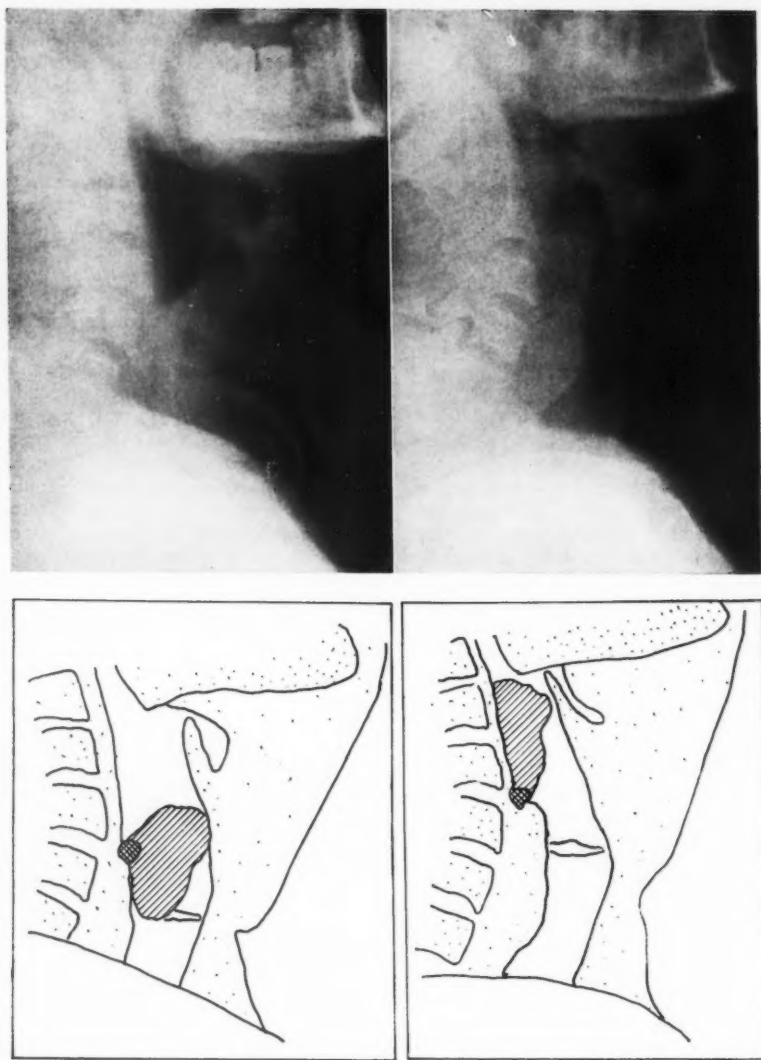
Lateral roentgenogram of the neck, showing a large pedunculated extrinsic carcinoma discovered by the roentgenologist when the patient was being studied, at the request of his internist, because of a wheeze. Note that the tumor flopped down into the supraglottic lumen on inspiration, or on leaning forward, with resultant dangerous respiratory obstruction.
